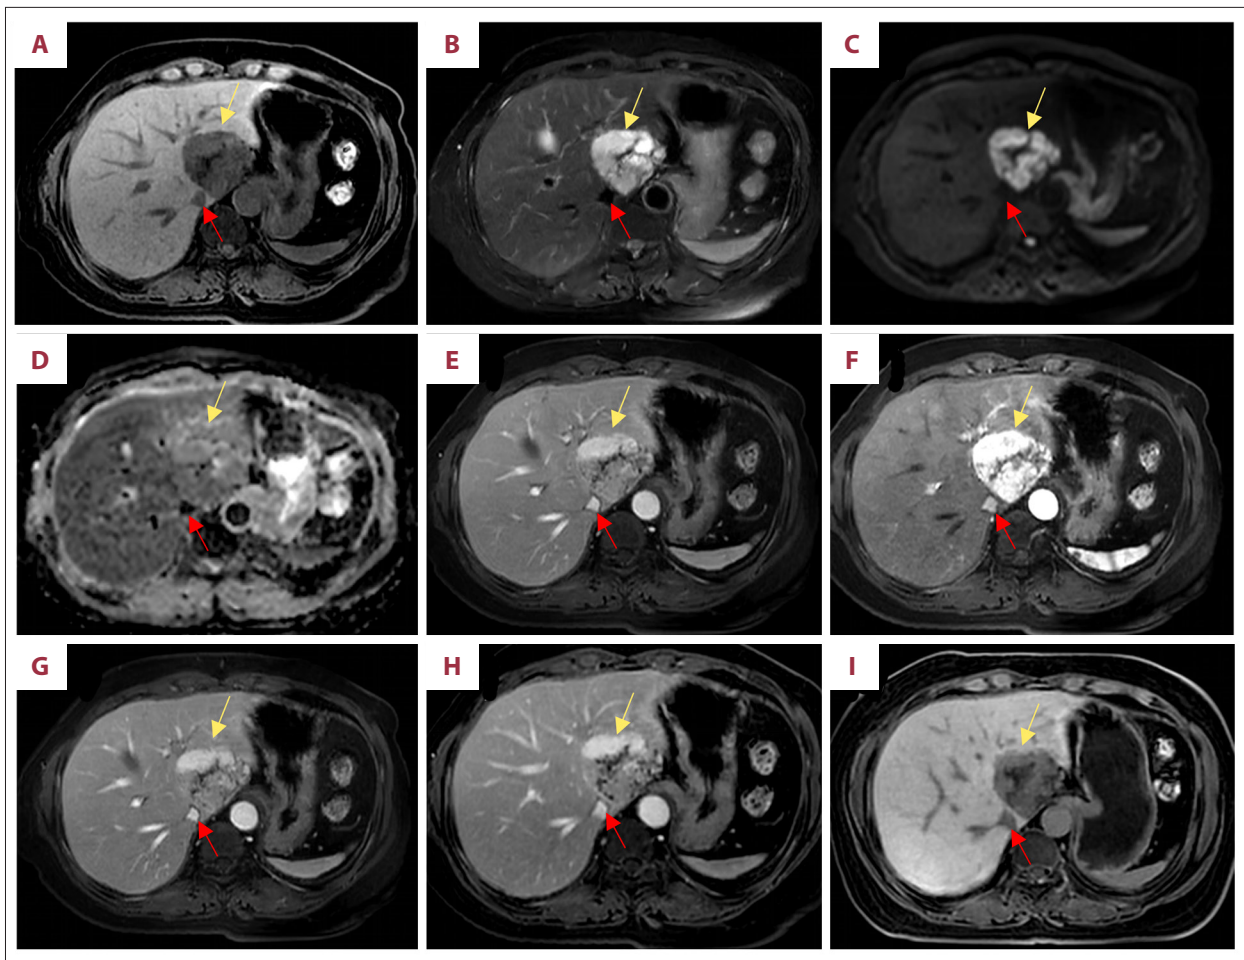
A 55-year-old woman with pathologically confirmed solitary fibrous tumor (orange arrow) in the liver, which is closely adjacent to the inferior vena cava (the red arrow). Preoperative MR examination suggests the tumor shows (A) hypointensity on T1-weighted imaging, (B) hyperintensity on fat-suppressed T2-weighted imaging, (C) exhibits restriction on diffusion-weighted imaging ($b=800$), and (D) apparent diffusion coefficient images. Dynamic contrast-enhanced MRI reveals that (E) the lesion with arterial phase hyperenhancement followed by (F) washout in the portal phase. (F-H) Persistent peripheral rim enhancement is noted in the portal, venous, and delayed phases. (I) On hepatobiliary phase imaging, the lesion is hypointense compared with the background liver parenchyma and contains an internally hypointense scar.
